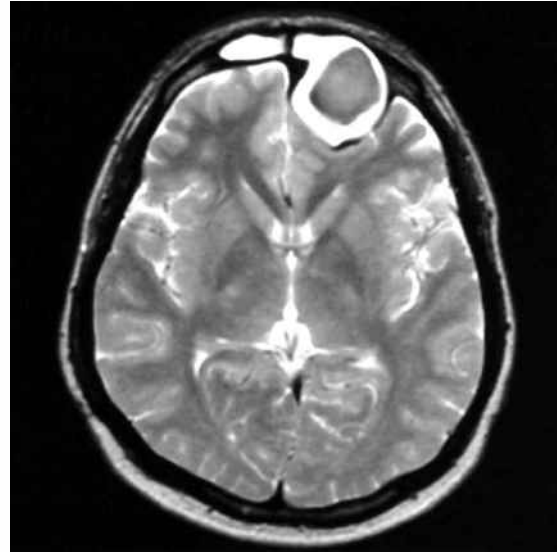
Axial T2-W MR image shows the left frontal mucocoele
